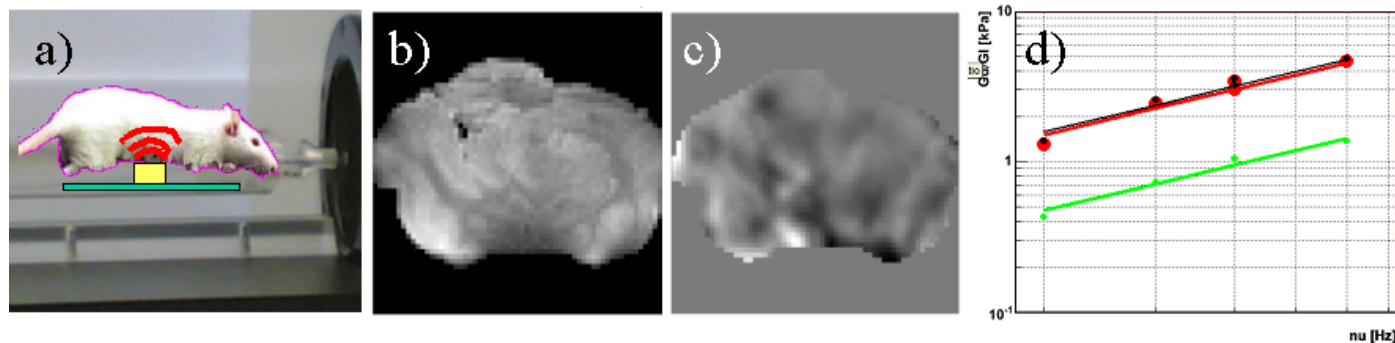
Experimental setup (a) for *in-vivo* and *in-vitro* experiments at the 7T horizontal MRI system. The object rests on the piezo-transducer, which vibrates in the up-down direction. *In-vitro* experiments with lamb brain [b]: magnitude MR image, c): y-component of curl] showed very good wave penetration at 100Hz. d) Dynamic modulus (red) and loss modulus (green) as a function of frequency (200-600 Hz) for liver tissue *ex-vivo*. The absolute value of the complex shear modulus is shown in black.
